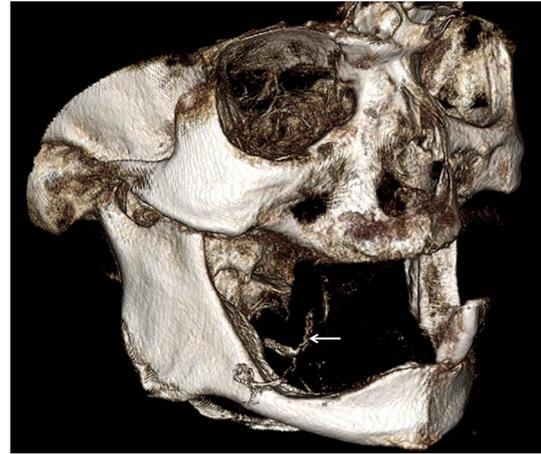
CBCT 3D rendering. Same patient as Fig. 7. A calcified facial artery is visualized buccal, superior, and lingual to the adjacent mandible (*arrow*). Mönckeberg medial calcific sclerosis has been associated with occlusive or peripheral vascular disease, Sturge-Weber syndrome, and metastatic calcification in hyperparathyroidism
